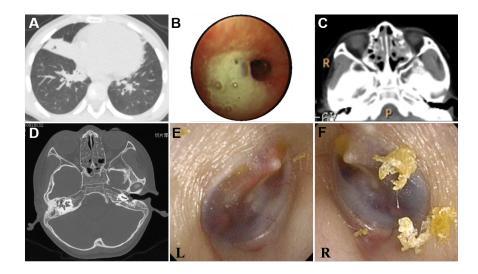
Clinical features of the elder sister. The chest high-resolution computed tomography (HRCT) scan showed bronchiectasis and atelectasis in the right middle lobe (A), sinusitis (C) and otitis media (D). Bronchoscopy indicated large amount of mucilage secretions in the right middle lobe. Otoscope findings of otitis media in left ear (E) and the right one (F).
